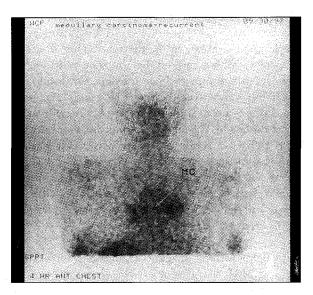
Recurrent medullary of the thyroid. Planar SRPTS study of the chest shows an area of increased concentration in the mediastinum. This corresponded with the enlarged lymph nodes seen on the CT of the chest.
